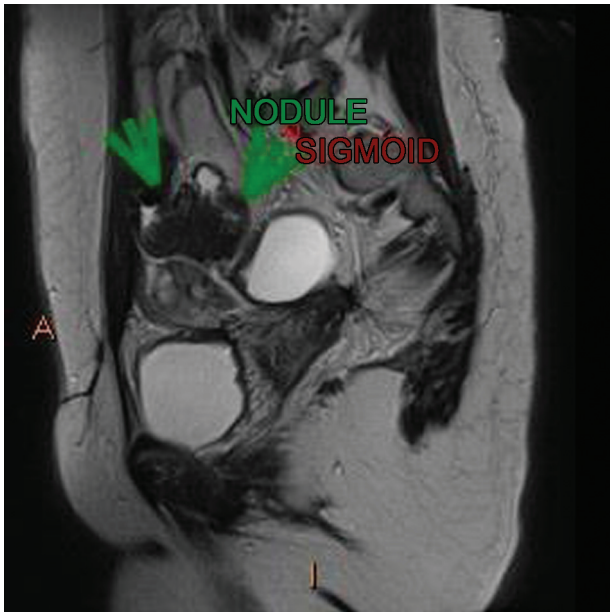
Magnetic resonance imaging scan showing an endometriotic nodule in the rectosigmoid.
